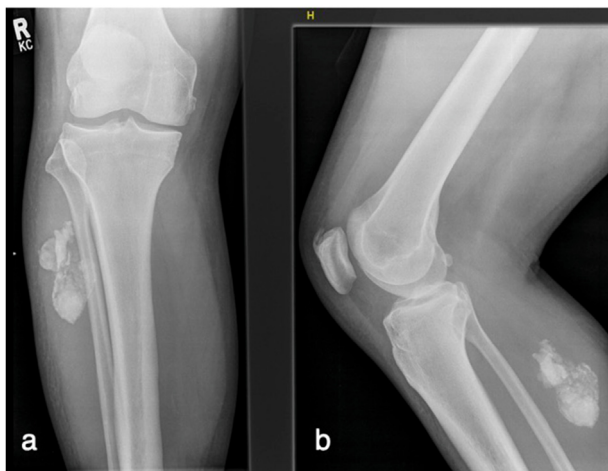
Myositis ossificans. AP (a) and lateral (b) radiographs of the right knee demonstrate a well-defined irregular lesion within the soft tissues of the proximal posterior lower leg. More mature osteoid is seen peripherally with less mature osteoid centrally. The patient had a history of trauma to the region, concordant with the imaging findings suggestive of myositis ossificans.
